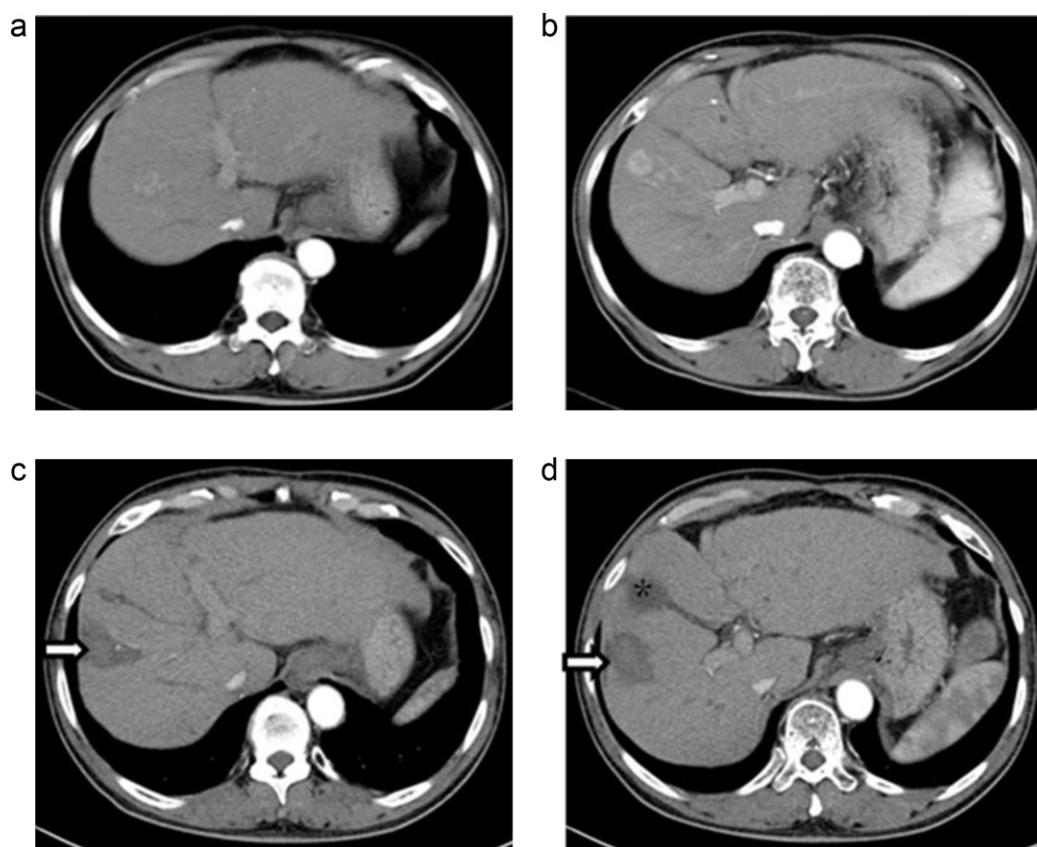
Contrast-enhanced CT showed a well-enhanced tumor in segment 8 in an early phase 3 years ago (a) and approximately 2 years later, a new lesion in segment 5 (b). Both were controlled with treated by repeated RFA and TACE (c, d). Arrow: ablated lesion. *: gallbladder.
